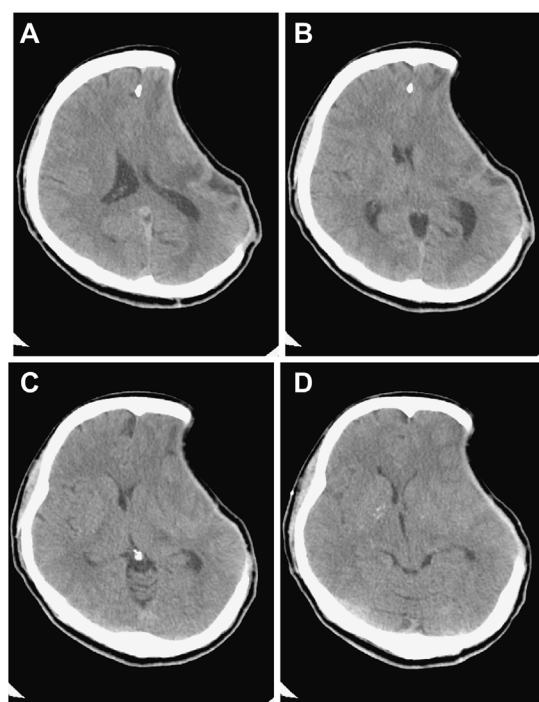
Noncontrast-enhanced CT (computed tomography angiography) of the brain on November 17, 2021, (A-D) shows a sunken skin flap with a herniation of the brain away from the craniectomy defect, resulting in a midline shift of \approx 1 cm to the right side with a decreased size of both lateral ventricles and the third ventricle
